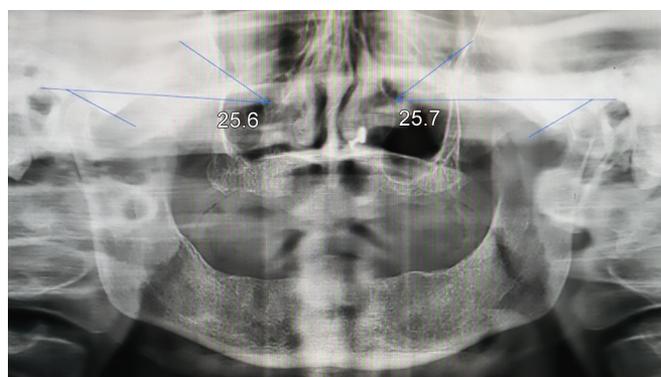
Sagittal condylar guidance on panoramic radiograph
